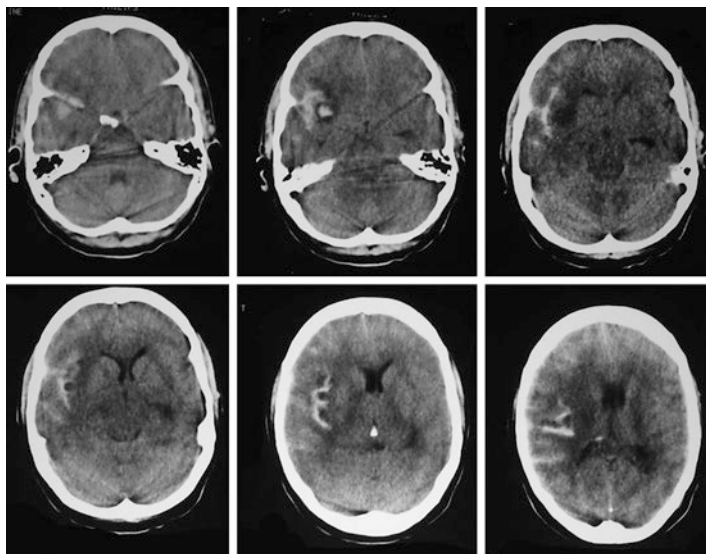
Non-contrast CT scan showing right sylvian fissure small hematoma and subarachnoid blood. *The important point is that the subarachnoid spaces are barely visible on the opposite side.* In less obvious cases, it is the areas corresponding to where the blood is seen on the right that are scrutinized for any evidence of blood. Can you try finding the CSF spaces on the left corresponding to the spaces where the blood is seen on the right?
